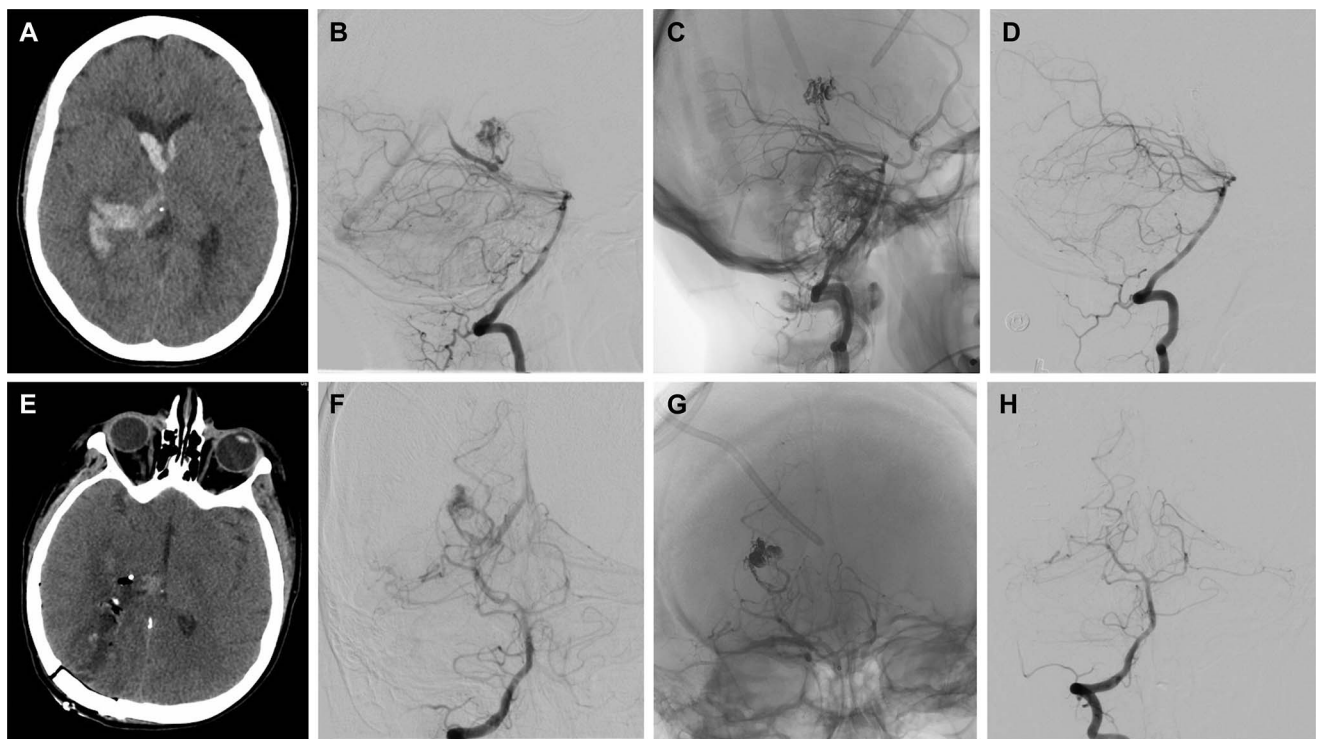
A 28-year-old woman with a hemorrhagic Spetzler-Martin grade III arteriovenous malformation. A, Axial head CT at the time of presentation with sudden onset headache, nausea, and vomiting demonstrates right thalamic region intracerebral hemorrhage with associated intraventricular hemorrhage and mass effect. B and F, Preoperative lateral and A-P digital subtraction angiography demonstrates an AVM arising from the right P3 branch with a nidus measuring 11 × 9 mm and with associated early deep venous drainage into the vein of Galen complex. C and G, Lateral and A-P projections after Onyx embolization of the nidus through 2 pedicle feeders by a right posterior cerebral artery microcatheterization. E, Axial head CT obtained postoperatively demonstrating a right occipital trajectory to the AVM. D and H, Lateral and A-P projections obtained after craniotomy for AVM resection demonstrating no residual early venous drainage and no residual AVM nidus. AVM, arteriovenous malformation; CT, computed tomography.
